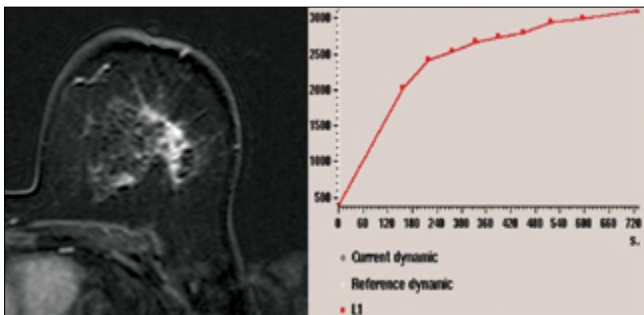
Pharmacokinetic curve of post-treatment dynamic contrast-enhanced MRI of Case 2. Mass lesion in the left breast showed approximately 40% reduction in dimension, the pharmacokinetic curve type shifted from type 3 to type 1. The MRI response type was considered as "partial response"
